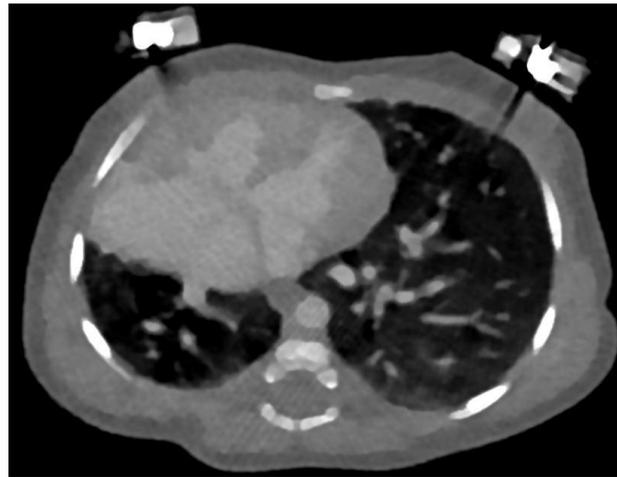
CT scan axial view showing dextroposition of the heart
